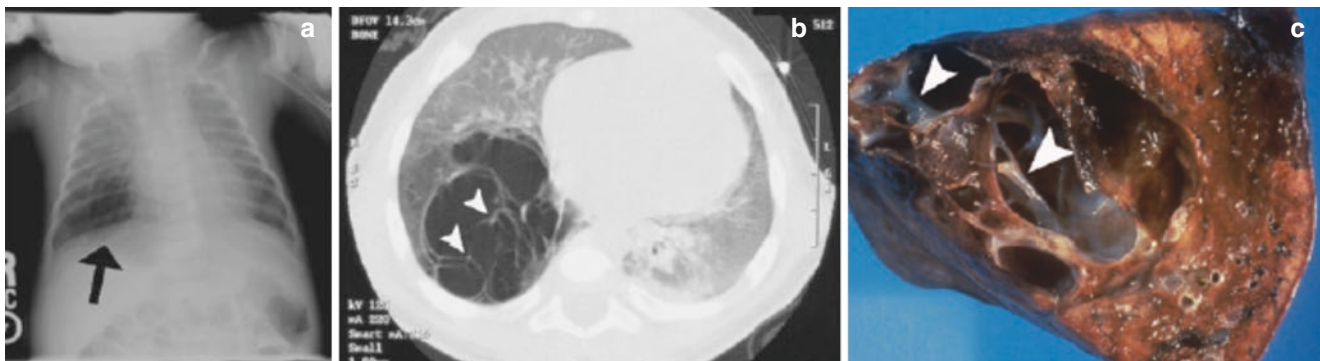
A 14-month-old ex-27 week premature infant with persistent pulmonary interstitial emphysema who was found to have a persistent lucent lesion at right lung base at age 3 months. (a) Frontal chest radiograph shows a lucent cyst (arrow) at the right base. (b) Axial lung window CT image demonstrates a multilocular air-filled cyst with thin
